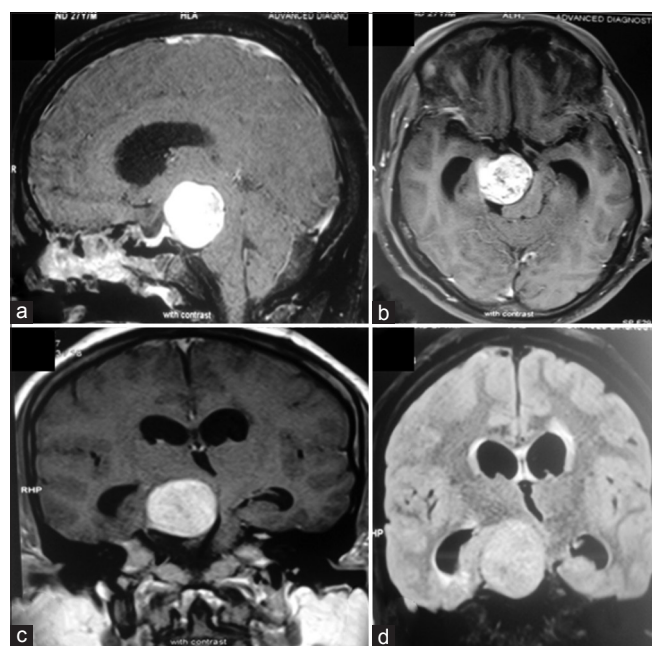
(a-d) Magnetic resonance imaging head axial cuts showing a well-defined oculomotor nerve schwannoma 3 cm × 2.5 cm × 3.5 cm, T1 isointense, T2 heterointense, homogeneous, contrast-enhancing mass lesion with lobulated appearance seen compressing the midbrain. (d) Coronal fluid-attenuated inversion recovery image with hyperintense, well-defined lesion
